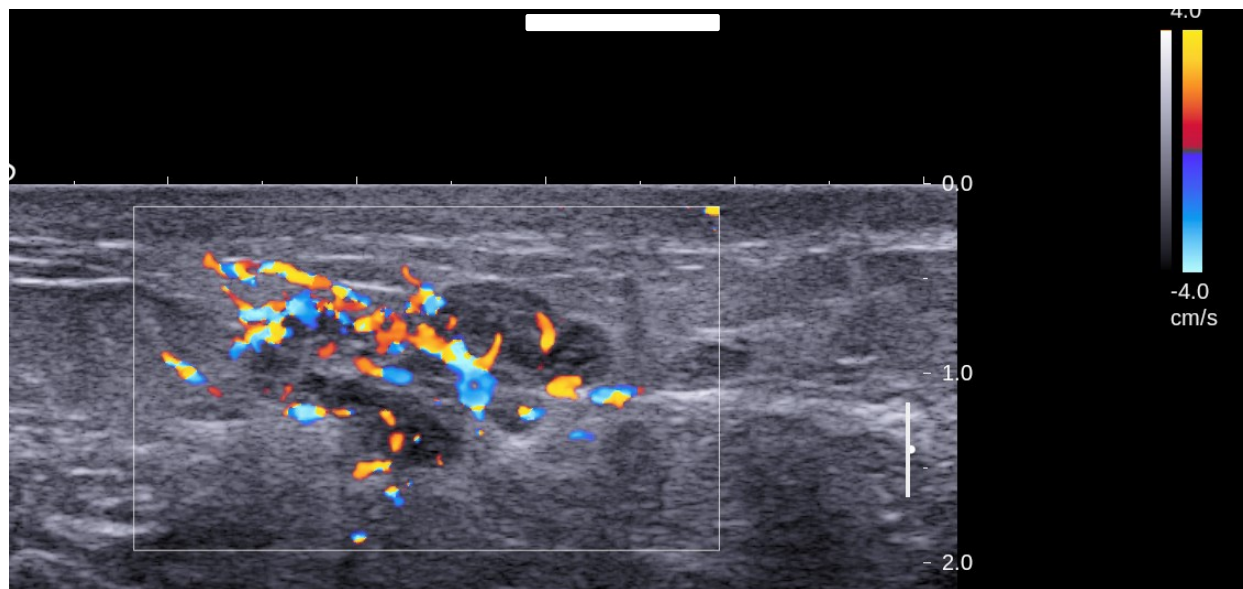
b: Color Doppler image of the same lesion, with irregular, internal penetrating vessel – hypervascular tumor.
